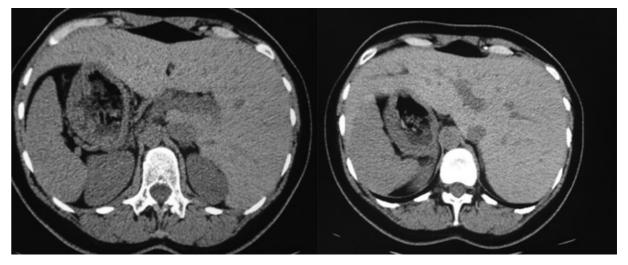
Axial CT scans: inversion of the abdominal organs – upper abdomen.
